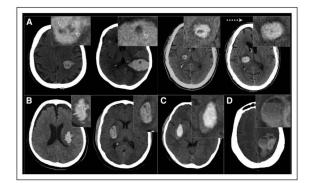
Examples of reported noncontrast computed tomography (NCCT) markers of hemorrhage expansion. Axial slices of acute noncontrast CTs in intracerebral hemorrhage (ICH). A, Hypodensities including from left to right, a swird sign, a black hole sign, and a central hypodensity in an ICH demonstrating significant expansion on repeated CT after 8 h. B, ICH with inregular margins and ICH with heterogeneous density (also qualifying for hypodensities and swirl sign. C, Blend sign. D, Fluid level.
